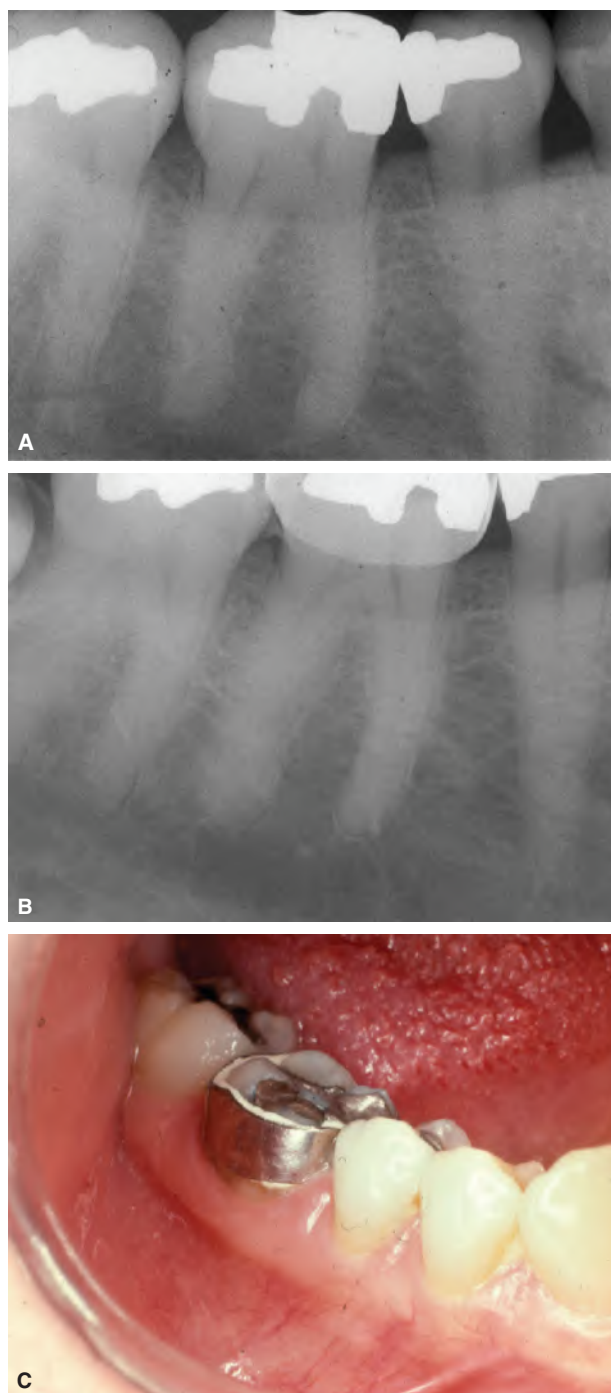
Diagnostic banding of a tooth with crown-originating fracture (COF). A. Radiograph of mandibular first molar with a symptomatic COF on the distal aspect of the tooth. Since the fracture line is in a mesio-distal orientation, it is not visible radiographically. B. With a pulpal diagnosis (based on symptoms and clinical findings) of reversible pulpitis, a band is cemented to bind the tooth together. C. Photograph taken 2 weeks later when the patient reports complete absence of symptoms. The patient can now be offered the option of a full coverage crown with the information that about 20% such teeth may need endodontic treatment later;⁶⁷ some patients may choose to have root canal treatment done prophylactically before crown placement.
